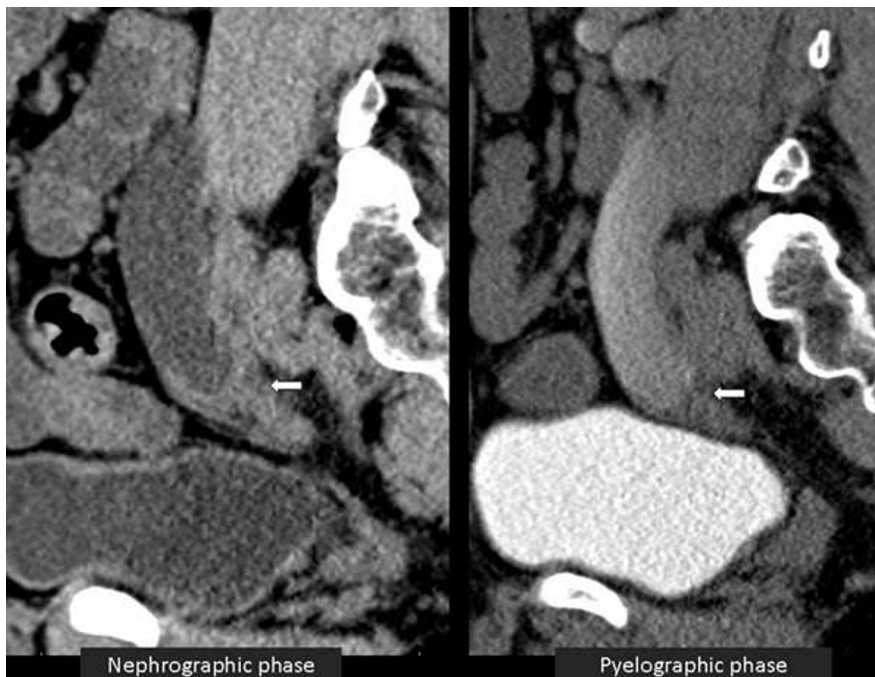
Case 2: 47-year-old male with IPT. Contrast-enhanced CT sagittal images in nephrographic and pyelographic phases show a distal ureteric stricture caused by a circumferential mass (arrow). The mass also shows mild contrast enhancement in the nephrographic phase.
